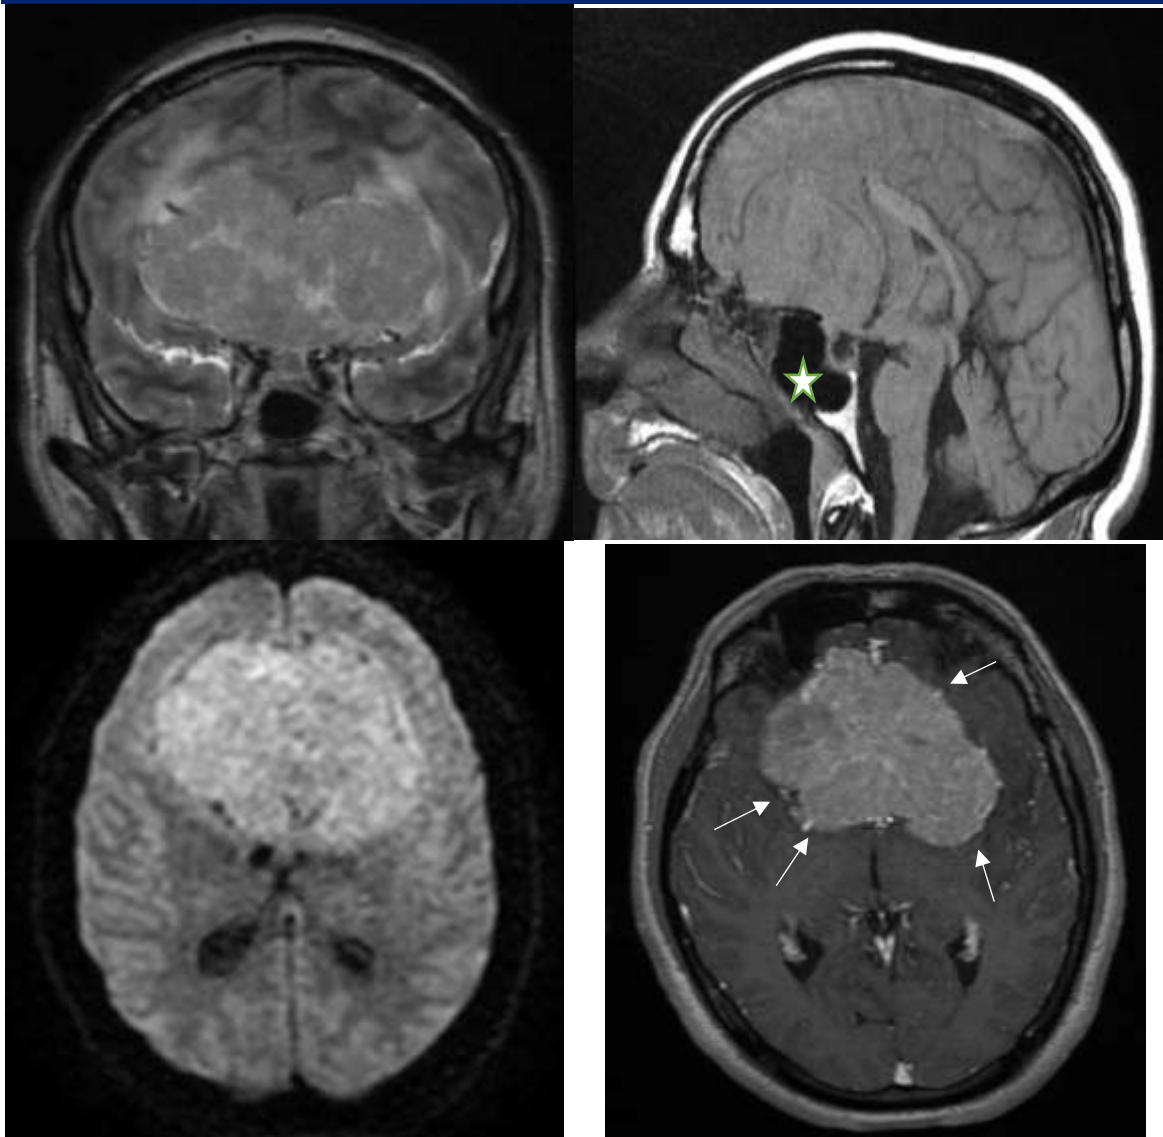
MRI in axial and coronal slices in coronal T2 , sagittal T1 , Diffusion and axial C+ sequences showing a large bilateral basifrontal Isosignal T1 , moderate high T2 signal, showing restricted diffusion and enhance homogeneously post gadolinium administration.
